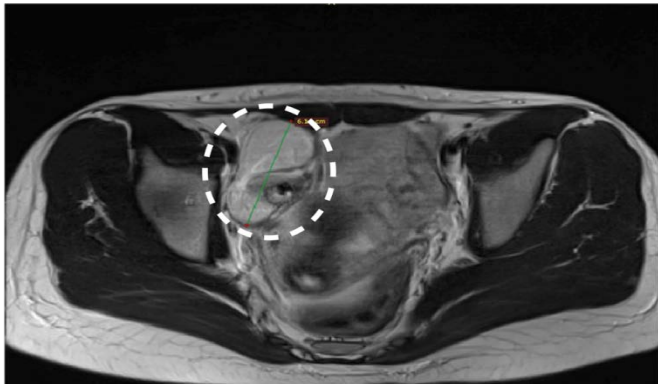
Axial Magnetic Resonance Imaging (MRI) reveals a well-defined ovarian mass in the right adnexa, which is consistent with a mature ovarian teratoma. The lesion exhibits benign imaging characteristics without evidence of invasion.
